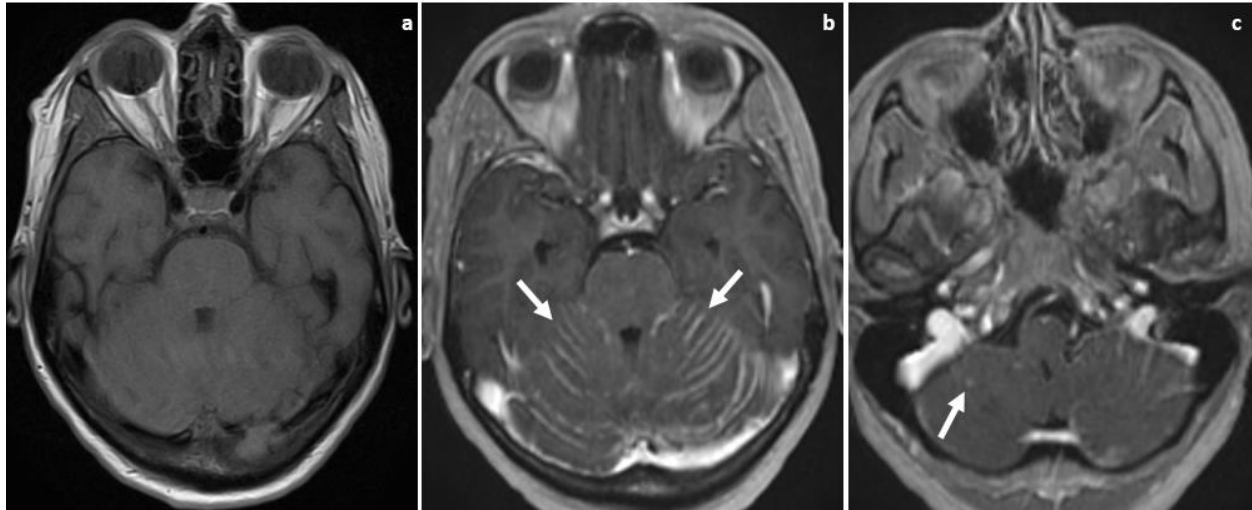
MRI of the brain. Pre-contrast T1-weighted sequence (a) demonstrating no hyperintense signal within the cerebellum. Post-contrast T1-weighted sequence (b) showing leptomeningeal enhancement within the cerebellar folia (white arrows). Post-contrast T1-weighted sequence (c) showing nodular small foci of enhancement (white arrow) concerning for solid intraparenchymal metastasis.
